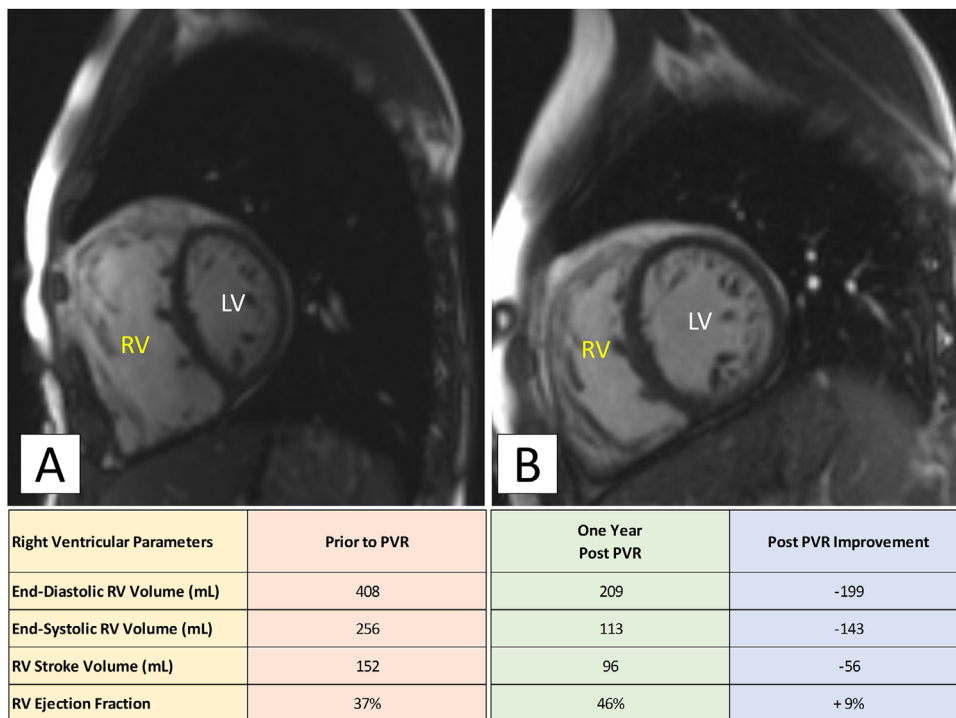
Severe pulmonic regurgitation post TOF repair on MRI cardiac MRI short-axis views at end-diastole pre (Panel A) and post (Panel B) TOF repair. The table highlights RV size and function improvements post-surgery. LV, left ventricle; RV, right ventricle.
